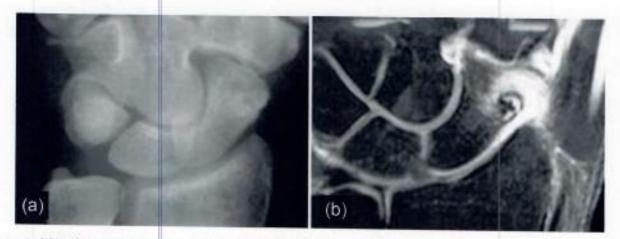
(a) Radiograph showing a suspicious area. (b) Magnetic resonance imaging showing reactive sclerosis around the central radiolucency (nidus).
